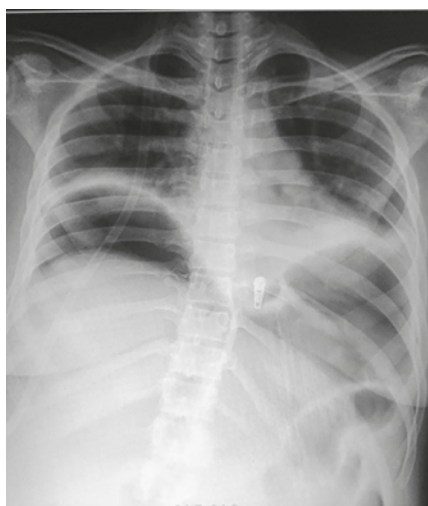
Patient's plain X-ray Abdomen showing free gas shadow beneath right dome of the diaphragm
